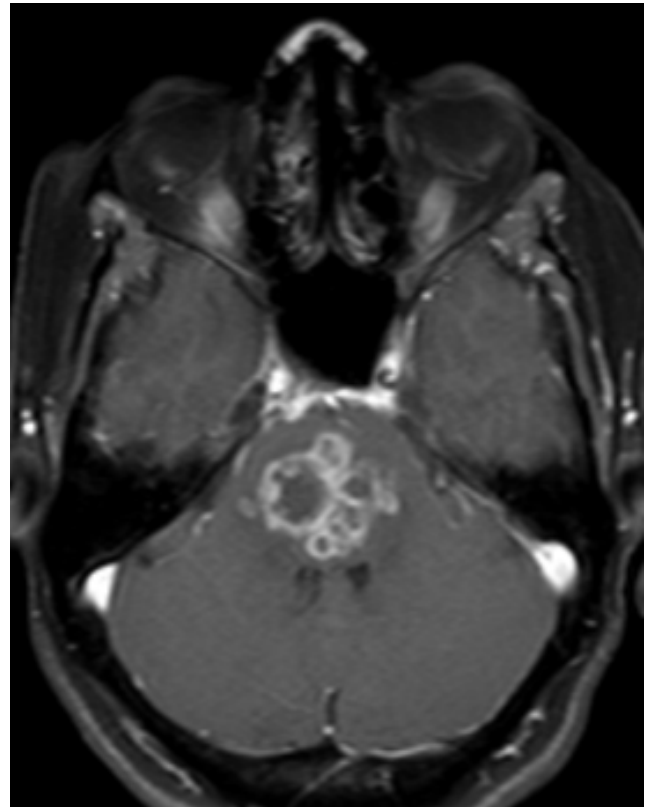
MRI Brain, Axial post gadolinium contrast T1 Weighted sequence, showing multiple discrete and conglomerate ring enhancing lesions in pons.
